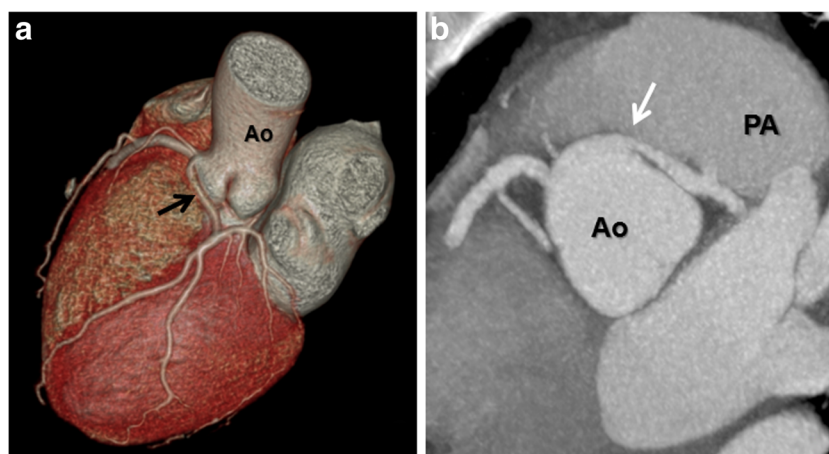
A 55-year-old female presented with exertional syncope. The evaluation culminated in a coronary CTA that demonstrated an anomalous left main coronary artery arising from the right sinus of Valsalva and coursing between the aorta and pulmonary artery. a The three-dimensional volume-rendered image demonstrates the malignant interarterial course of the anomalous left main (*arrow*) coronary artery between the aorta and pulmonary artery (subtracted to visualize the left
